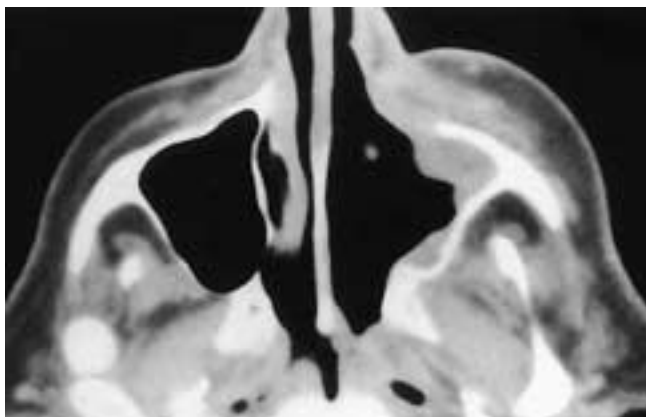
Axial CT scan on a patient after a left medial maxillectomy. There is a nodular fullness in the soft tissues filling the postoperative cavity. This smooth nodule was a retention cyst and not recurrent tumor.
